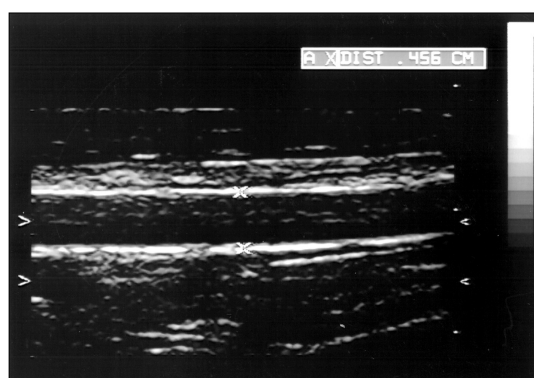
High-resolution ultrasound of the brachial artery the distance between asterisks in this case is 0.456 cm, which measures the distance from media to opposite media.
